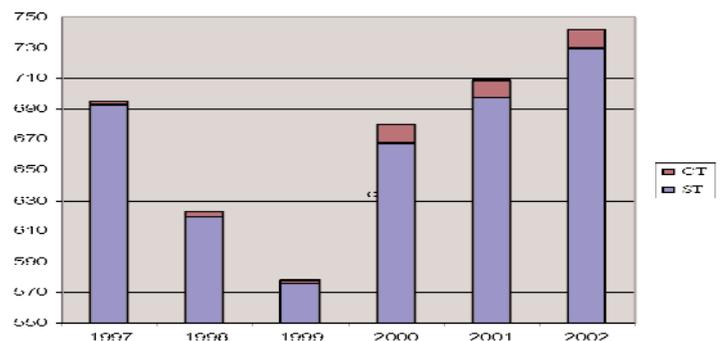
The significant increase in the number of CT patients as opposed to the marginal increase in the total number of ST patients followed in the period between 1997 and 2002
